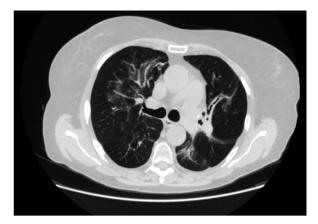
High-resolution chest computed tomography performed in December 2021 showing continuous regression of the inflammatory lesions in the lungs
